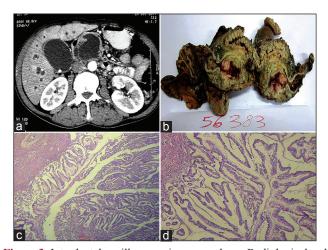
Intraductal papillary mucinous neoplasm: Radiological and pathological findings (a) Computed tomography scan showing a well-delineated heterogeneous hyperdense cystic mass (b) Macroscopic findings: Irregular dilated mucin-filled main pancreatic duct with foci of hemorrhage and thickening of the surrounding pancreas (c) Intraductal proliferation of columnar mucin-producing cells arranged in a papillary pattern (hematoylin and eosin  $\times$  40) (d) Intraductal papillary mucinous neoplasm: Papillae lined by columnar cells with pseudo-stratified cigar-shaped nuclei and basophilic cytoplasm (hematoylin and eosin  $\times$  200)
